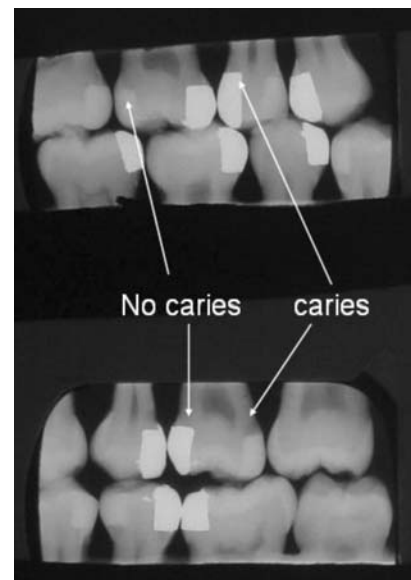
Examples of bitewing images demonstrate either secondary caries present or absent
